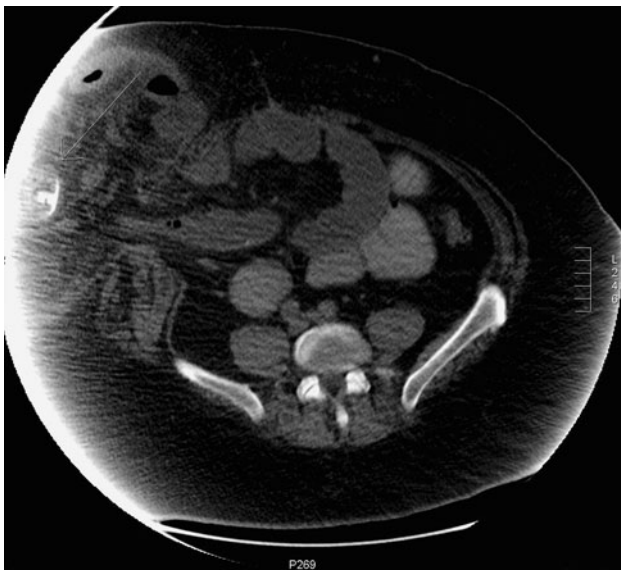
Abdominal CT scan: deflated intragastric balloon (arrow)
